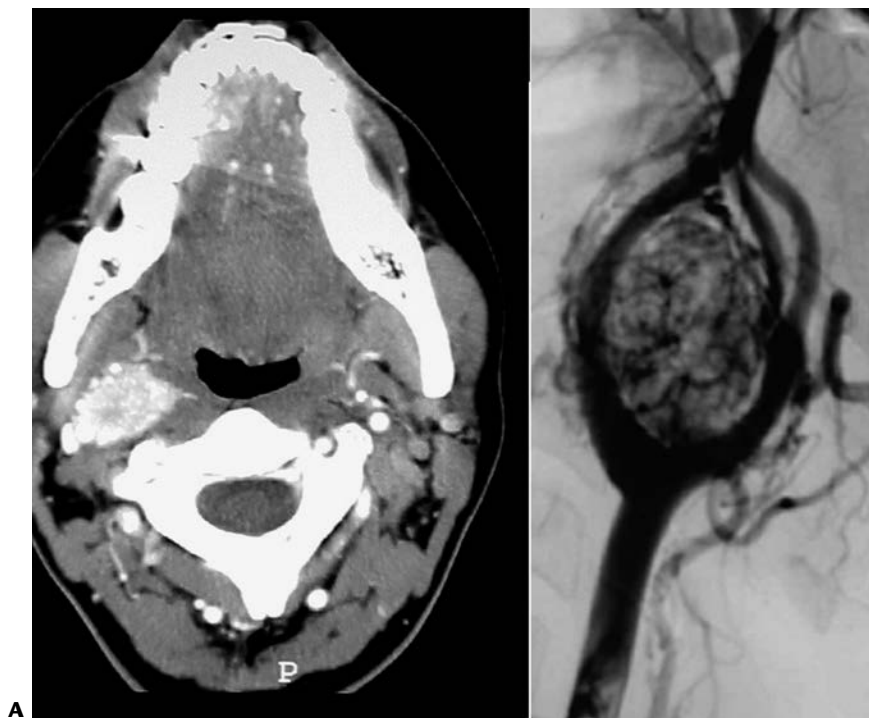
Characteristic CT (A) and angiogram (B) of carotid body tumor.
